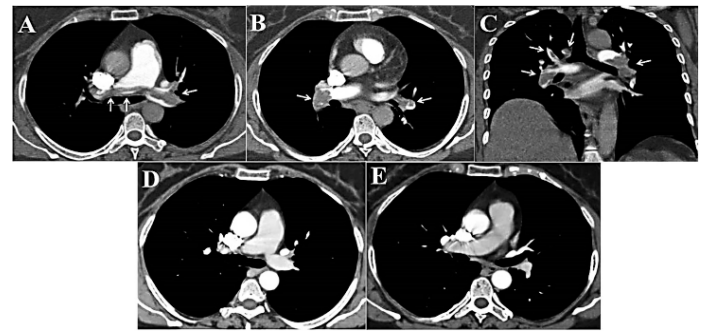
63-year-old female patient. Axial (A, B) and coronal (C) pulmonary CT Angiography images reveal bilateral massive pulmonary embolism extending from the carina to both main pulmonary arteries (arrows). Follow-up axial CT angiography images (D, E) show completely resorption of bilateral massive pulmonary embolism.
